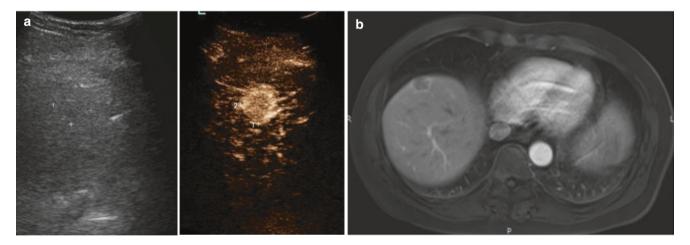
An isoechoic liver metastasis lesion from rectal cancer in a 58-year old. The lesion showed complete hyperenhancement during arterial phase both on contrast enhanced ultrasound (CEUS) (a) and on
